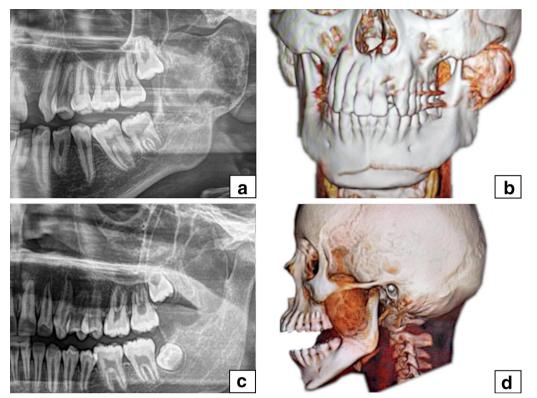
Panoramic radiograph and three-dimensional (3D) reconstructed CT images of ABCs affecting the condyle (A, B) and coronoid process (C, D)of the mandible.
